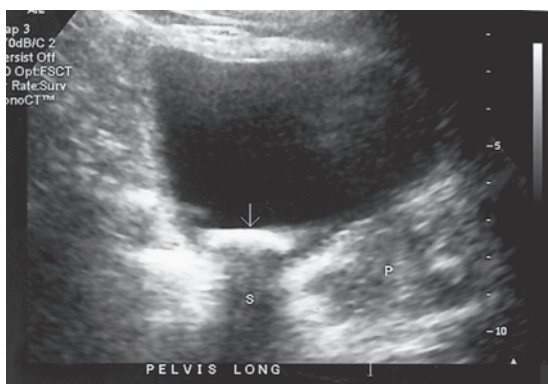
Bladder calculus. A longitudinal sonogram shows hyperechoic calculus (arrow) with acoustic shadowing (S) within the bladder. The prostate (P) is seen inferior to the bladder.
